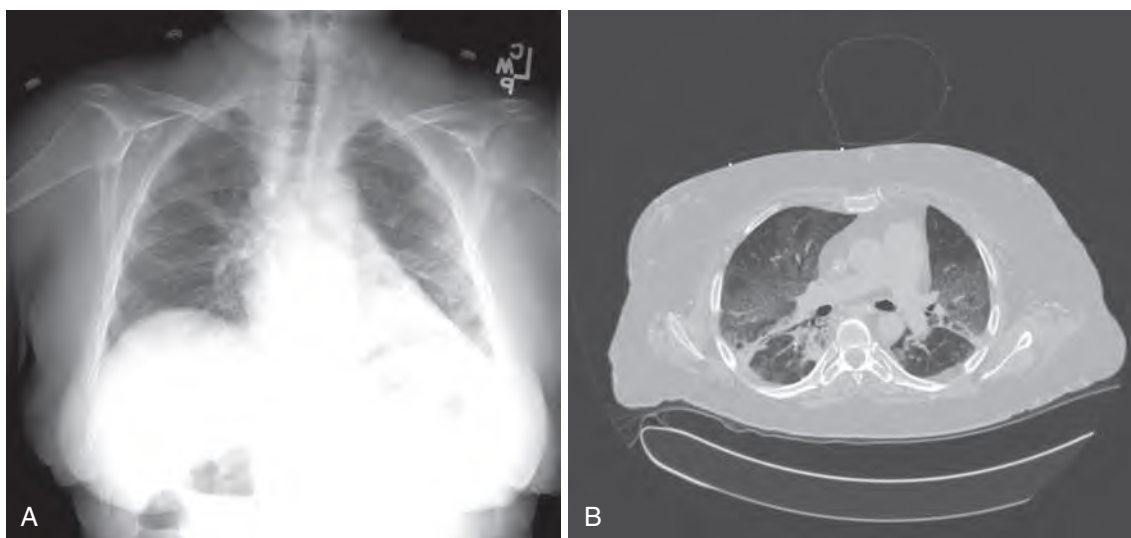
(A) This 32-year-old white female is status postrenal transplant approximately 10 years ago and now presents with progressive, nonproductive cough and low-grade fever over the past 2 months. A routine chest radiograph reveals diffuse interstitial infiltrates without pulmonary nodules or a focal pulmonary infiltrate. (B) A computed tomography scan obtained on the same patient reveals diffuse interstitial infiltrates bilaterally with the "crazy-paving" pattern typical of pulmonary alveolar proteinosis. Diagnosis was confirmed by bronchoscopy with the finding of copious milky-white material on bronchoalveolar lavage. At that time she was also found to have a concomitant *Mycobacterium avium* complex pulmonary infection.
